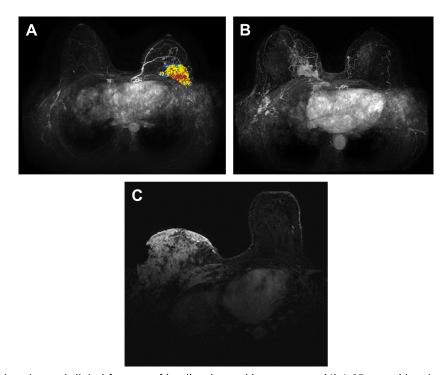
MR imaging and clinical features of locally advanced breast cancer. (A) A 25-year-old patient presenting with triple-negative invasive ductal carcinoma nuclear grade 3 measuring 4.5 cm in left upper outer quadrant and small breast size. (B) A different patient with 3.9-cm right upper inner quadrant mixed invasive ductal and lobular carcinoma nuclear grade II/III and chest wall invasion. (C) A third patient with invasive breast cancer replacing the breast and invading the skin. Patient also has chest wall invasion as manifested by enhancement of the pectoralis and intercostal muscles.
